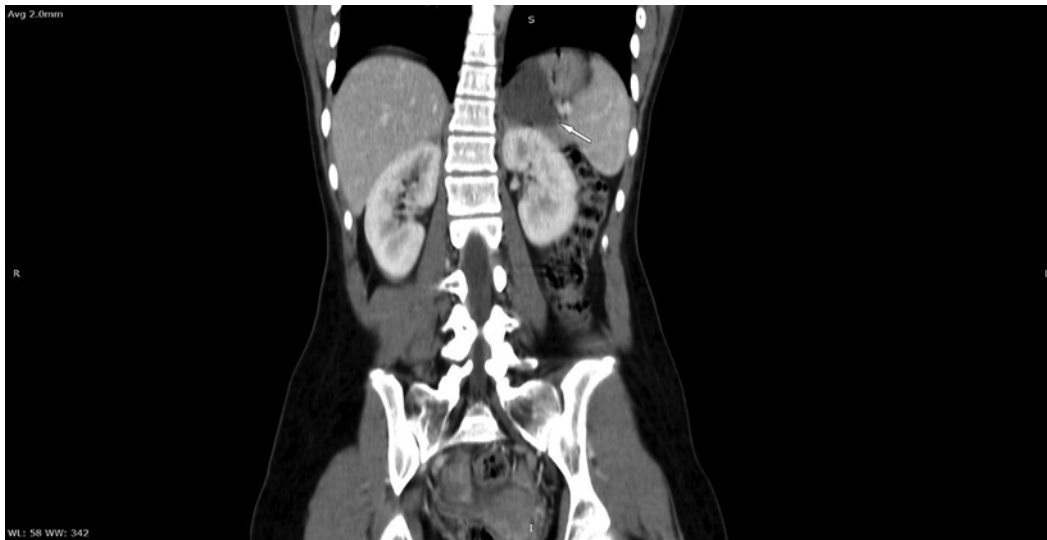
Abdominal CT with IV contrast, coronal section, shows a cystic lesion between the stomach and upper pole of the left kidney (white arrow).
